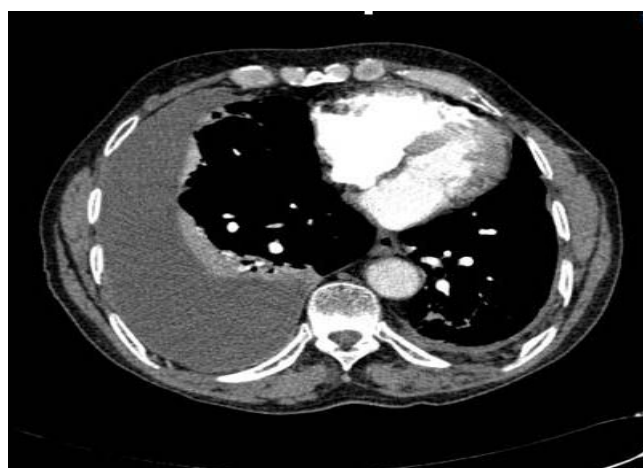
Contrast-enhanced chest CT scan showing a right-sided pleural effusion.
